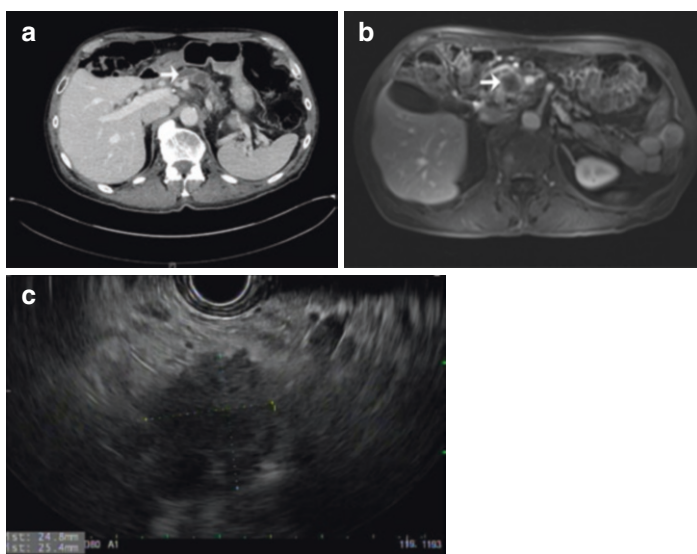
Radiologic appearance of a pancreatic ductal adenocarcinoma on (a) CT, (b) MRI, and (c) EUS. All three modalities shown here highlight an ill-defined centrally hypoechoic mass within the head of the pancreas
